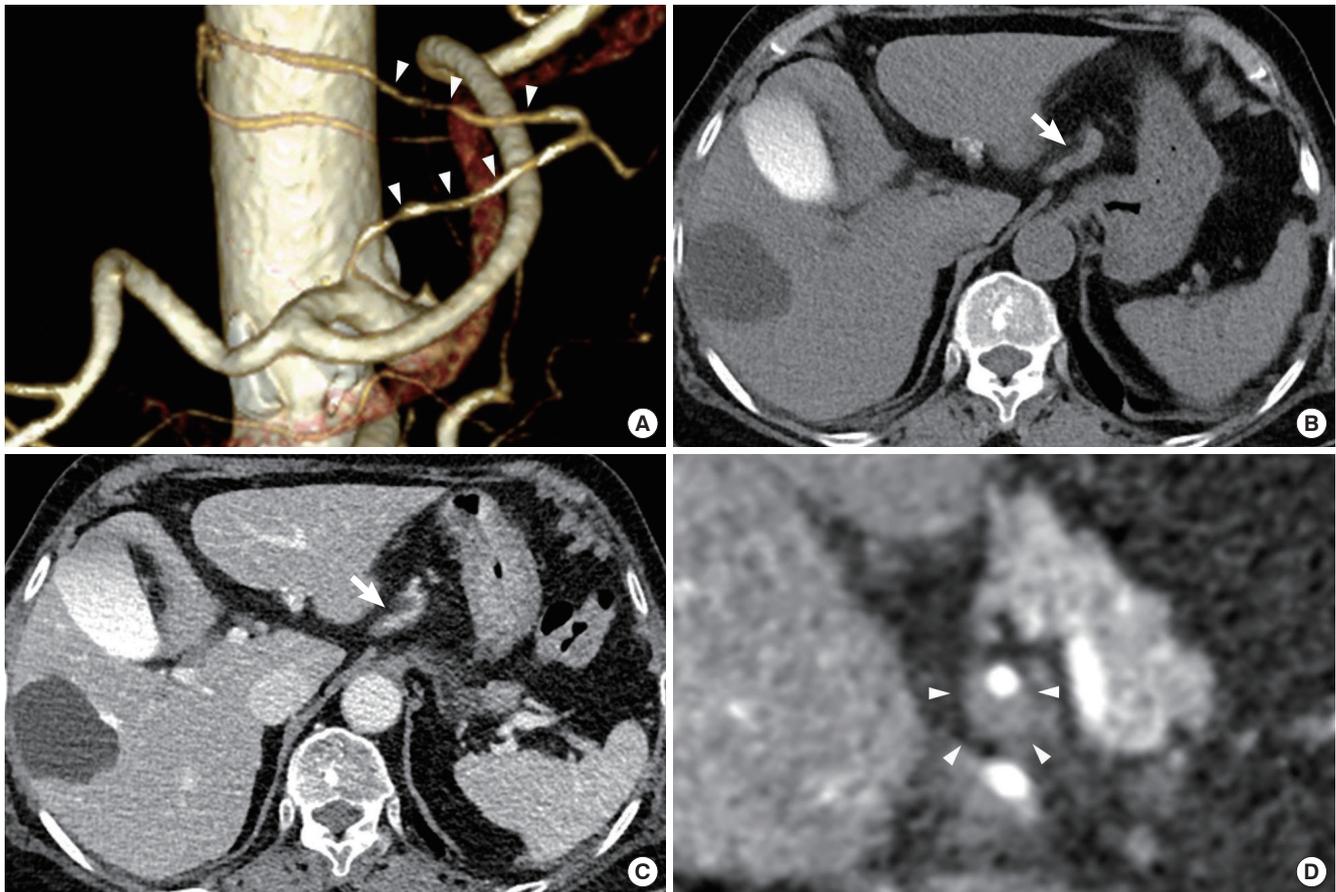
Multidetector computed tomography (MDCT) angiography of a 77-year-old woman with sudden severe epigastric pain. (A) The three-dimensional volume rendering image shows anatomical variant of the replaced left hepatic artery arising from the left gastric artery (LGA) with diffuse irregular luminal narrowing (arrowheads). (B) The non-enhanced CT scan shows high density of thickened LGA (arrow), measuring 40 Hounsfield units. (C) The enhanced CT scan shows diffuse luminal irregularity of LGA (arrow) with associated fat stranding. (D) The curved multiplanar reformatted image shows eccentric wall thickening of LGA (arrowheads), representing dissection with acute intramural hematoma.
